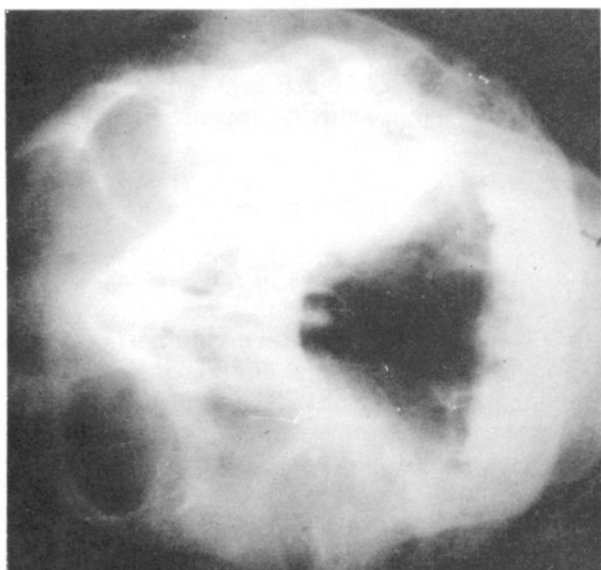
Skull x-ray film showing a lesion in the left frontoethmoidal region occupying and remodelling the sinus and opacification in the left maxillary sinus.
